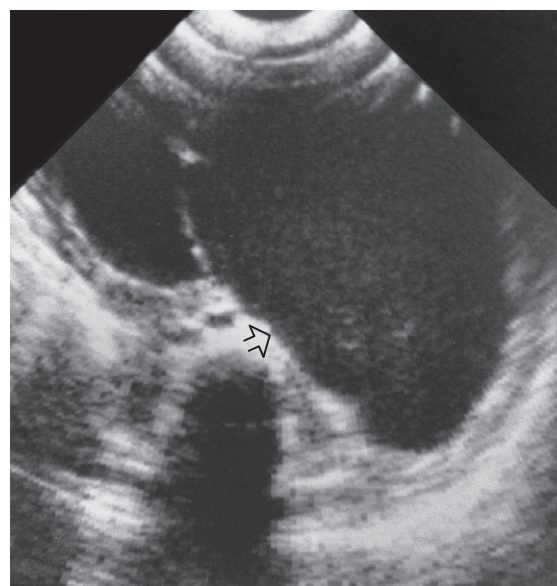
Ultrasonogram showing a large, multilocular cystic mass in the anterior abdomen, consistent with the diagnosis of a mesenteric cyst. Fine internal echoes represent hemorrhage within the cyst (arrow).
